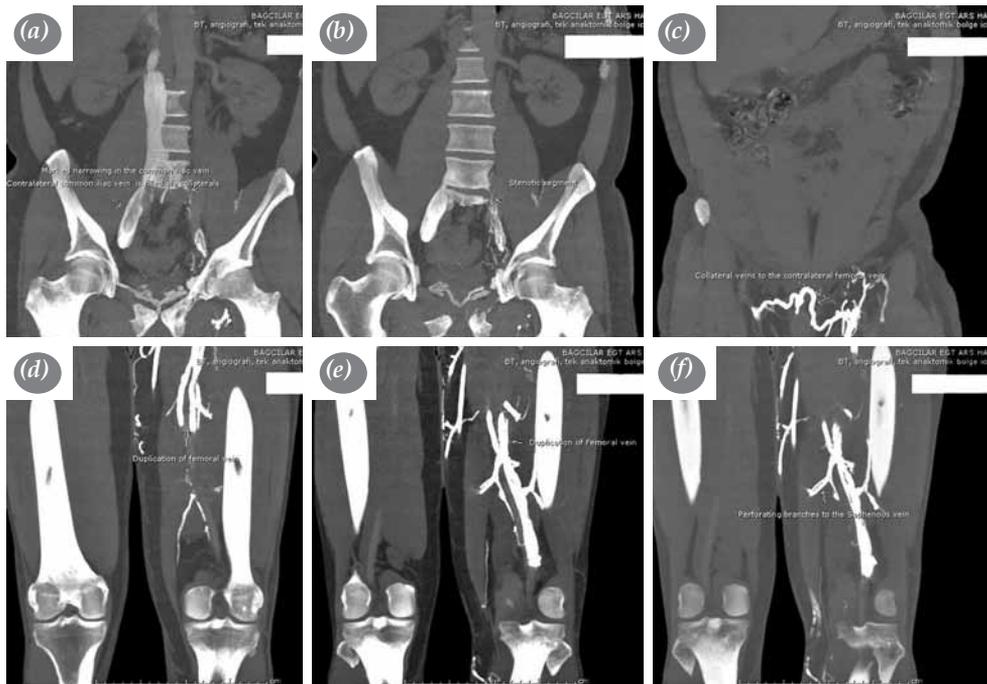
Control computed tomographic venography of a patient three months after the procedure.
